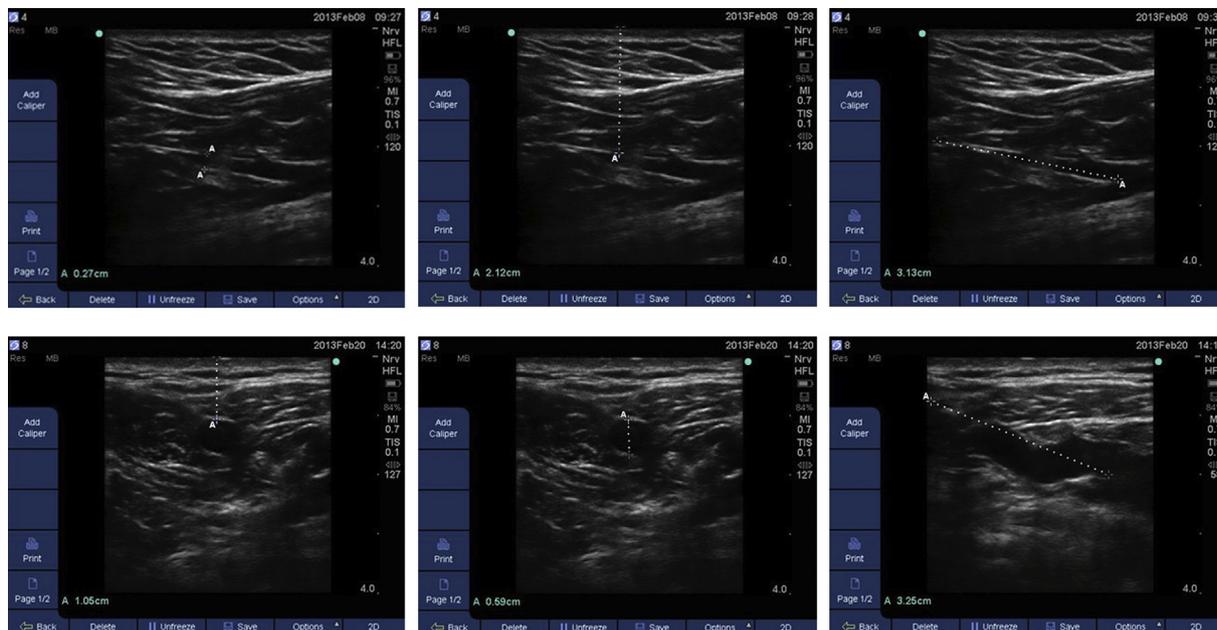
Measurement of ultrasonographic parameters of the right cephalic vein in two different patients. First row: cephalic vein diameter, depth of subcutaneous tissue, length of cephalic vein at the site of totally implantable venous access device (TIVAD) insertion. Second row: depth of subcutaneous tissue, cephalic vein diameter, length of cephalic vein at the site of TIVAD insertion.
